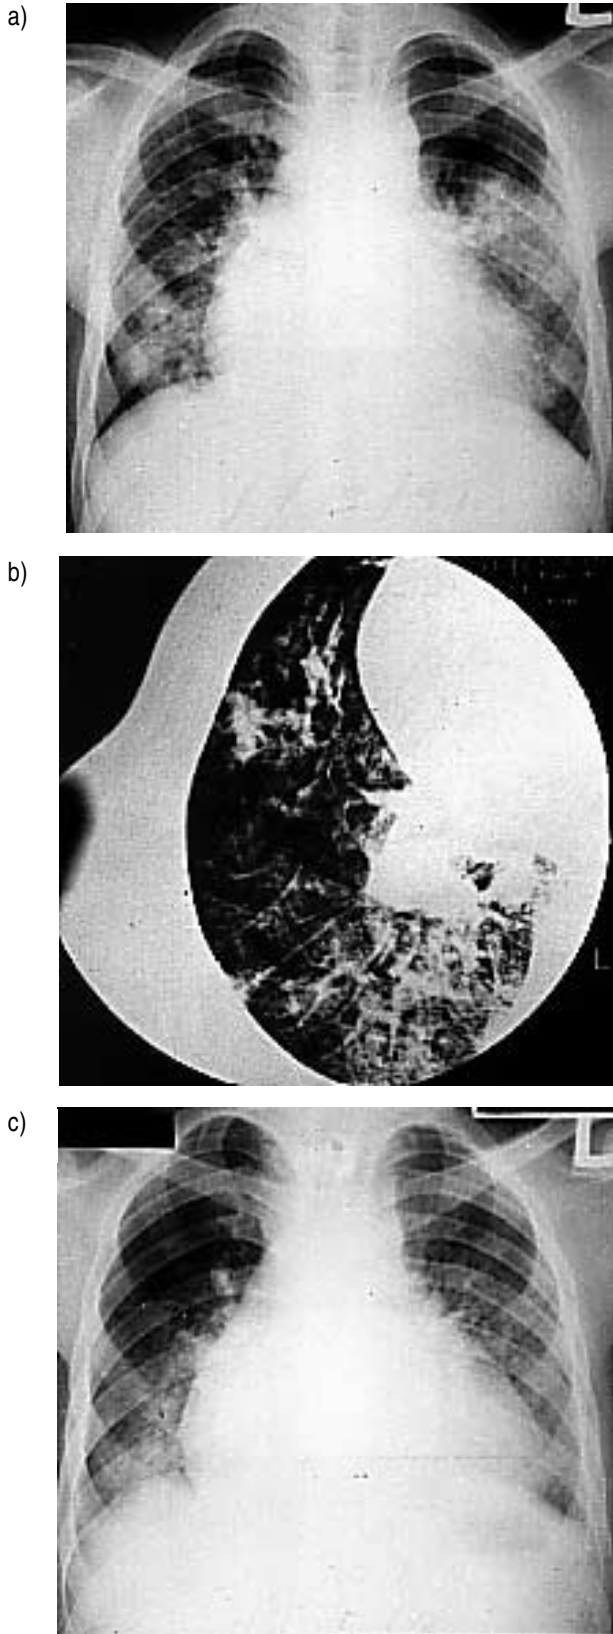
a) Chest roentgenogram at the first admission shows bilateral patchy infiltration with cardiomegaly. b) High resolution computed tomographic scan at the first admission shows patchy consolidations with preservation of normal lung regions. c) Chest roentgenogram at subsequent admission shows similar findings to those of the first admission.
